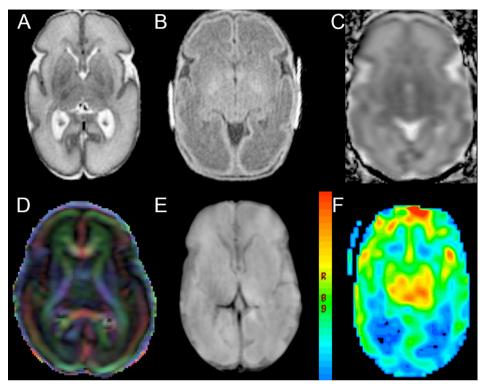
Applied MRI sequences: A: axial T2-weighted fast-spin echo; B: axial 3D T1-SPGR; diffusion tensor imaging, C: apparent diffusion coefficient-map and D: color-coded directionality map (red represents fibers in the left-right direction, blue represents fibers in the superior-inferior direction, and green represents fibers in the anterior-posterior direction); E: susceptibility weighted imaging, and F: arterial spin labeling.
